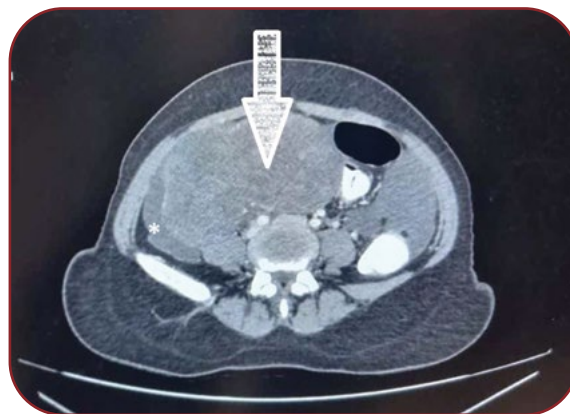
Contrast enhanced computed tomography scan abdomen (axial view) showing solid nodular ovarian mass (white arrow) and ascites (asterisk)
